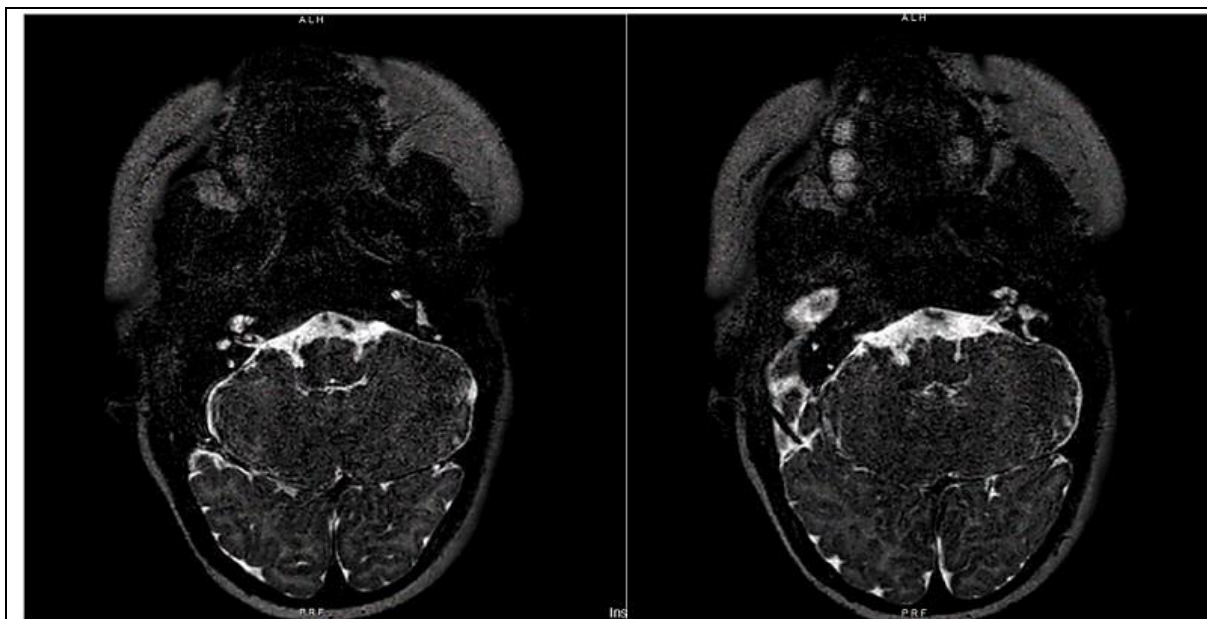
Child's two-month-old MRI showing the inner ear was free of abnormalities and that the cochlea was functioning normally
